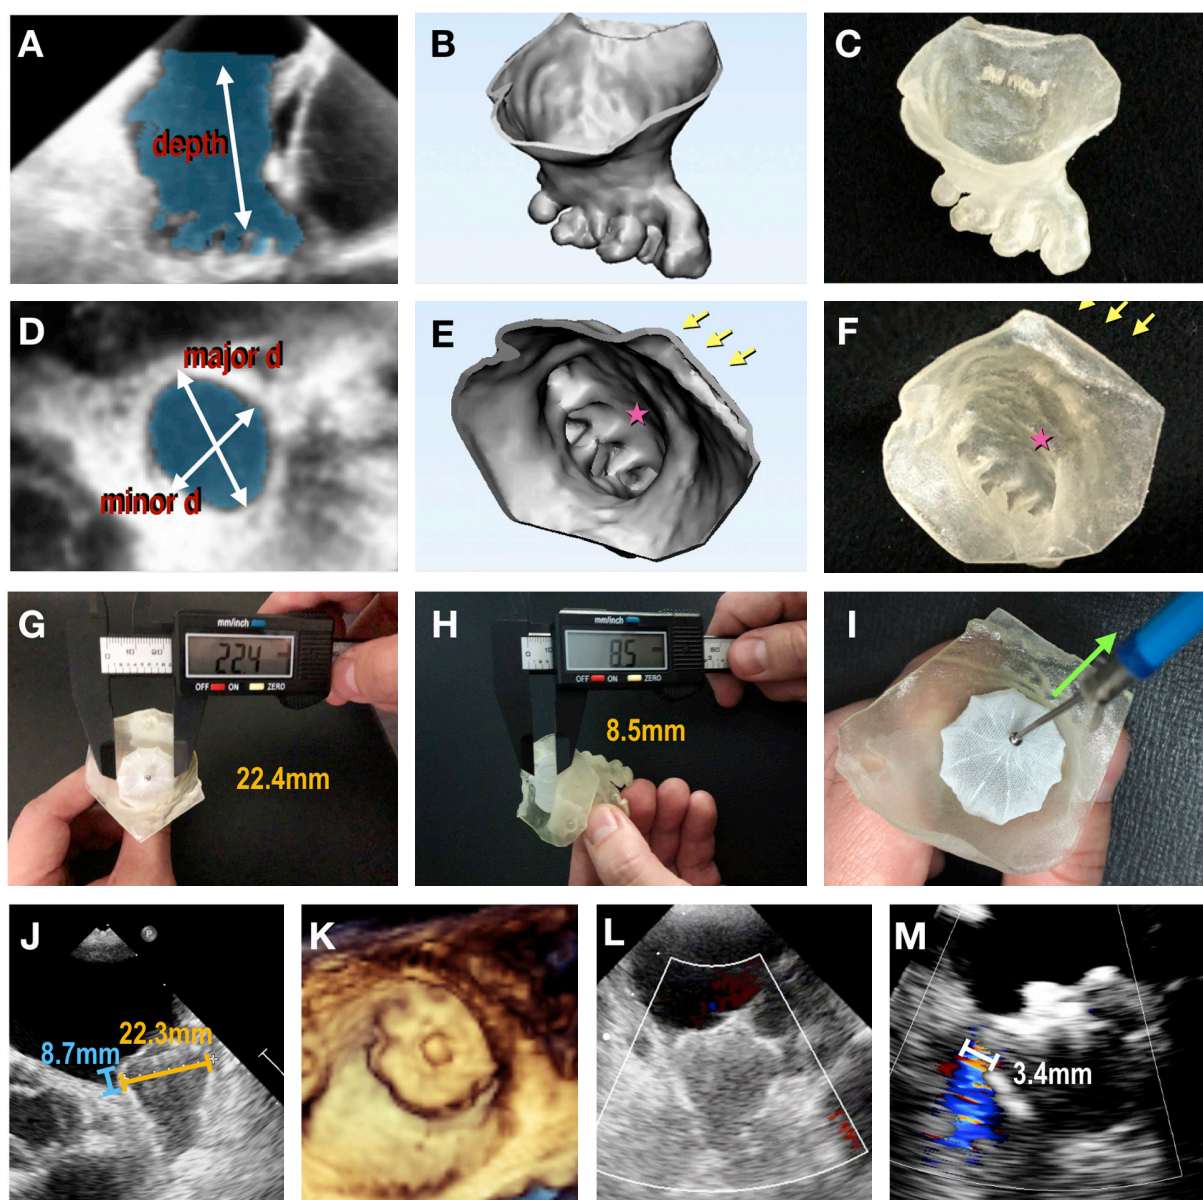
Echocardiography-based 3D printing of patient-specific models. Segmentation of LAA (shaded area) from 3D TEE data (A, D) is turned into a digital object (B, E), and printed using tissue-mimicking material (C, F). The major and minor ostial diameters and depth of the LAA are measured. Arrows denote pulmonary vein ridge; stars denote appendicular trabeculations. Closure devices are then sized and placed within the 3D model (G-I), and device compression and (H) protrusion are measured using a digital caliper. Device stability is assessed using the tug-test (I). Device placement visualized on TEE (J-L), and color Doppler assessment showing no peri-device leak (M). Reprinted with permission from Fan *et al.*^[20]. LAA: left atrial appendage; TEE: trans-esophageal echocardiogram; CT: computed tomography; 3D: three-dimensional
